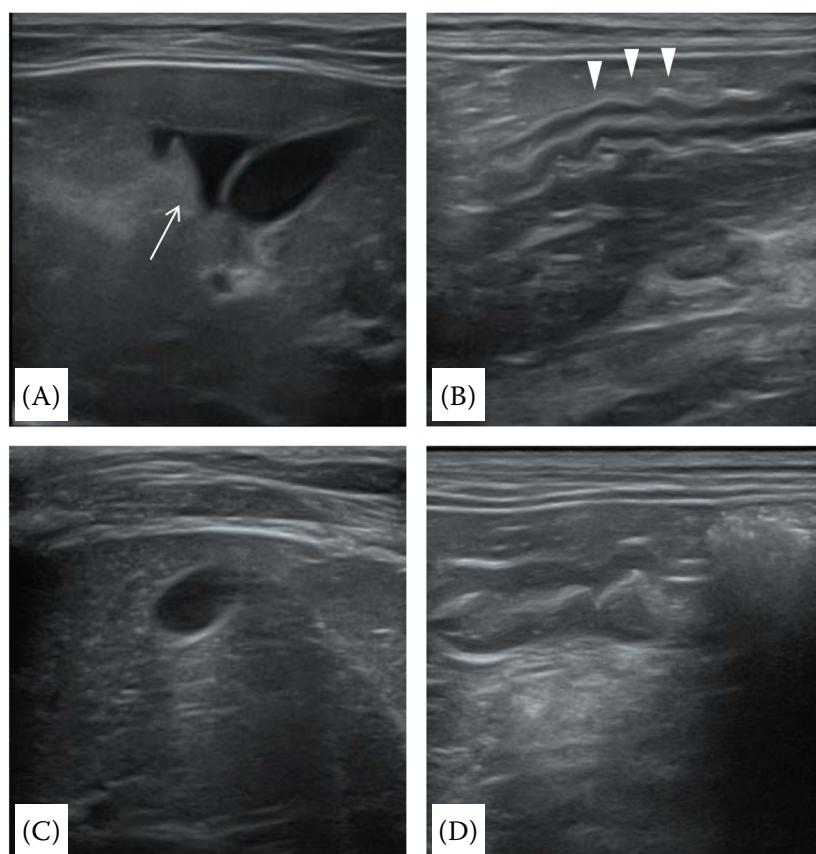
Abdominal ultrasonographic images at the initial assessment and follow-up examination
